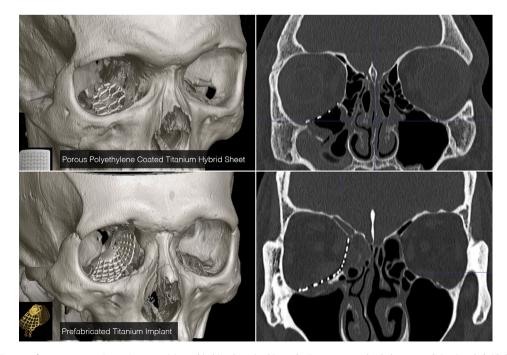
Post-operative CT scans of two representative patients receiving orbital implants in this study. Top: porous polyethylene coated titanium hybrid sheet, Bottom: preformed titanium implant.
